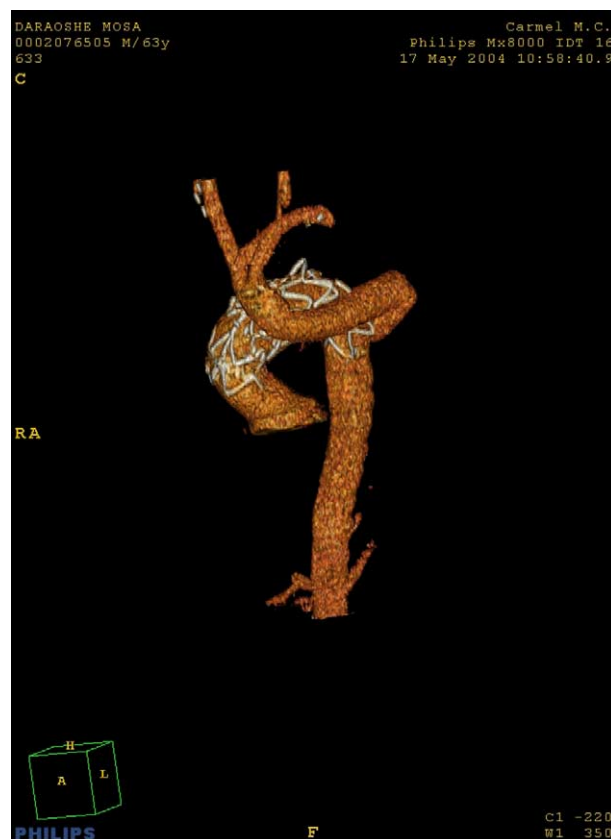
CTA reconstruction of aortic arch covered with stent graft and bypass from descending aorta to arch vessels.
